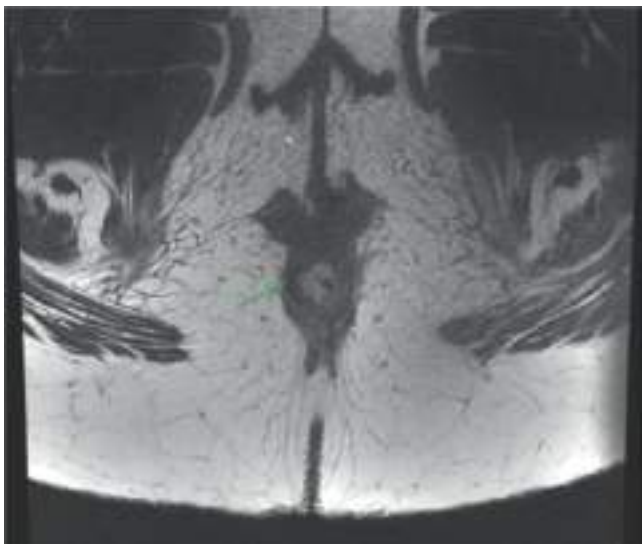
Anal cancer: pretreatment MRI T2 oblique, suspicion for focal tumor invasion into the right lateral internal anal sphincter (green arrow).
